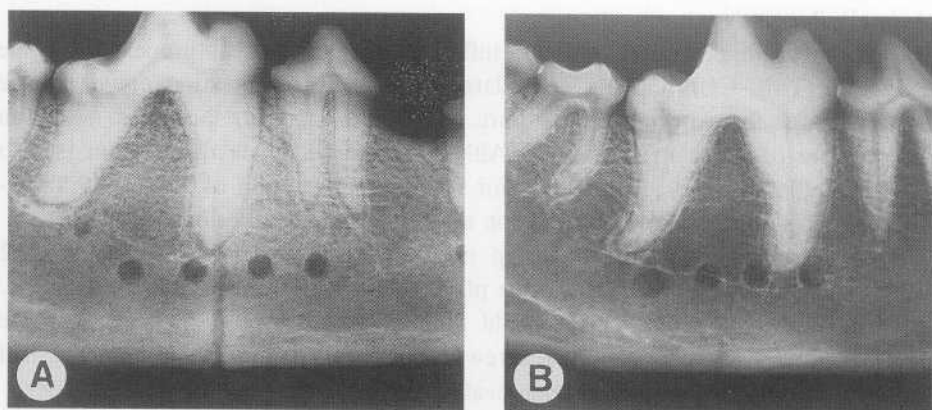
Lateral radiographs of the fracture site. (A) At 6 weeks good repositioning of the fragments and no dislocation can be observed. (B) At 18 weeks the fracture line has faded.
